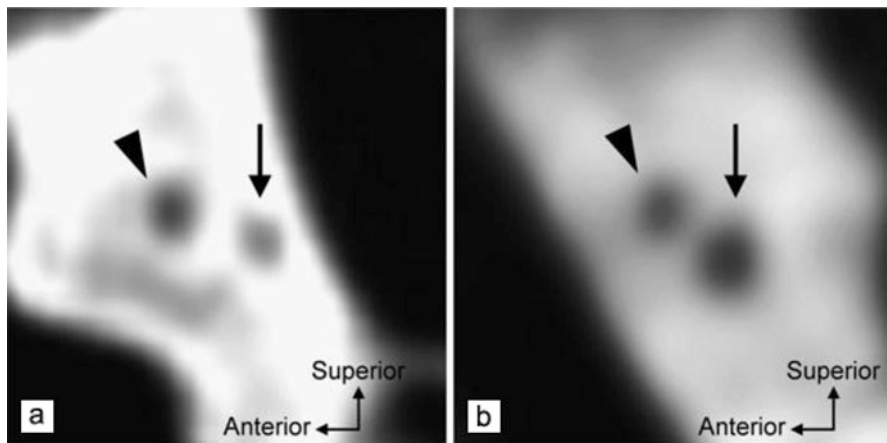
Evaluation of relative diameter of the vestibulocochlear nerve compared to the facial nerve at CPA using MRI. MRI shows the vestibulocochlear nerve (*arrows*) and the facial nerve (*arrowheads*) at the CPA. (a) “CN7 > CN8,” (b) “CN7 ≤ CN8” (Cited from Ref. [29] with permission)
